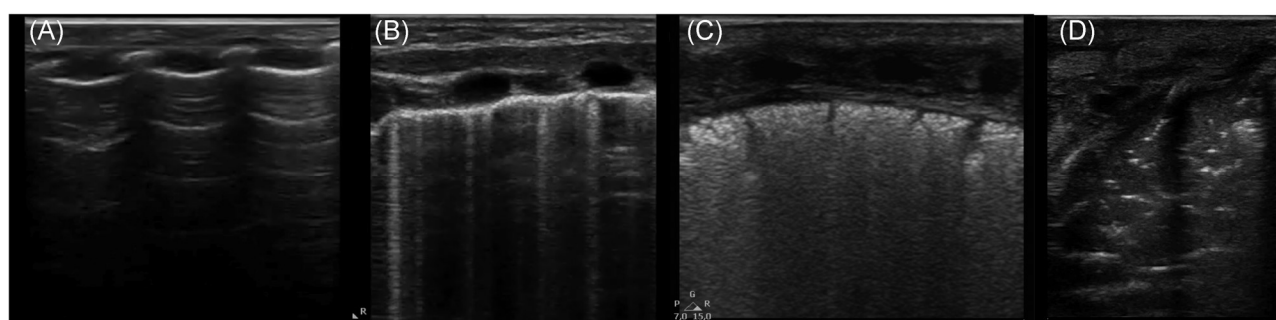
The figure shows the progressive reduction of air content in the lung from a normal condition (A) to interstitial syndrome (B), to white lung (C) up to consolidation (D). Three ultrasound patterns are also recognizable in the figure as classified by Raimondi et al.¹¹ Type 1—full hyperechoic image of the lung fields or “white lung” (C); Type 2—prevalence of B lines, lung sliding sign present (B) Type 3—A-lines predominance, lung sliding sign present (A). Lung ultrasound score for each area is attributed according to the following criteria: 0, A-pattern (defined by the presence of only A-lines; A); 1, B-pattern (defined as the presence of three or more B-lines, well spaced; B); 2, severe B-pattern (defined as the presence of crowded and coalescent B lines with or without consolidations limited to subpleural space; C); and 3, extended consolidation (D)¹⁵
